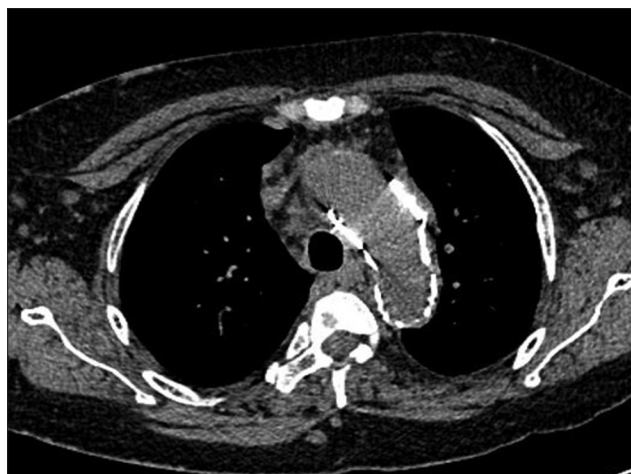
Postoperative computed tomography of the chest showing repair of the aortic arch aneurysm
